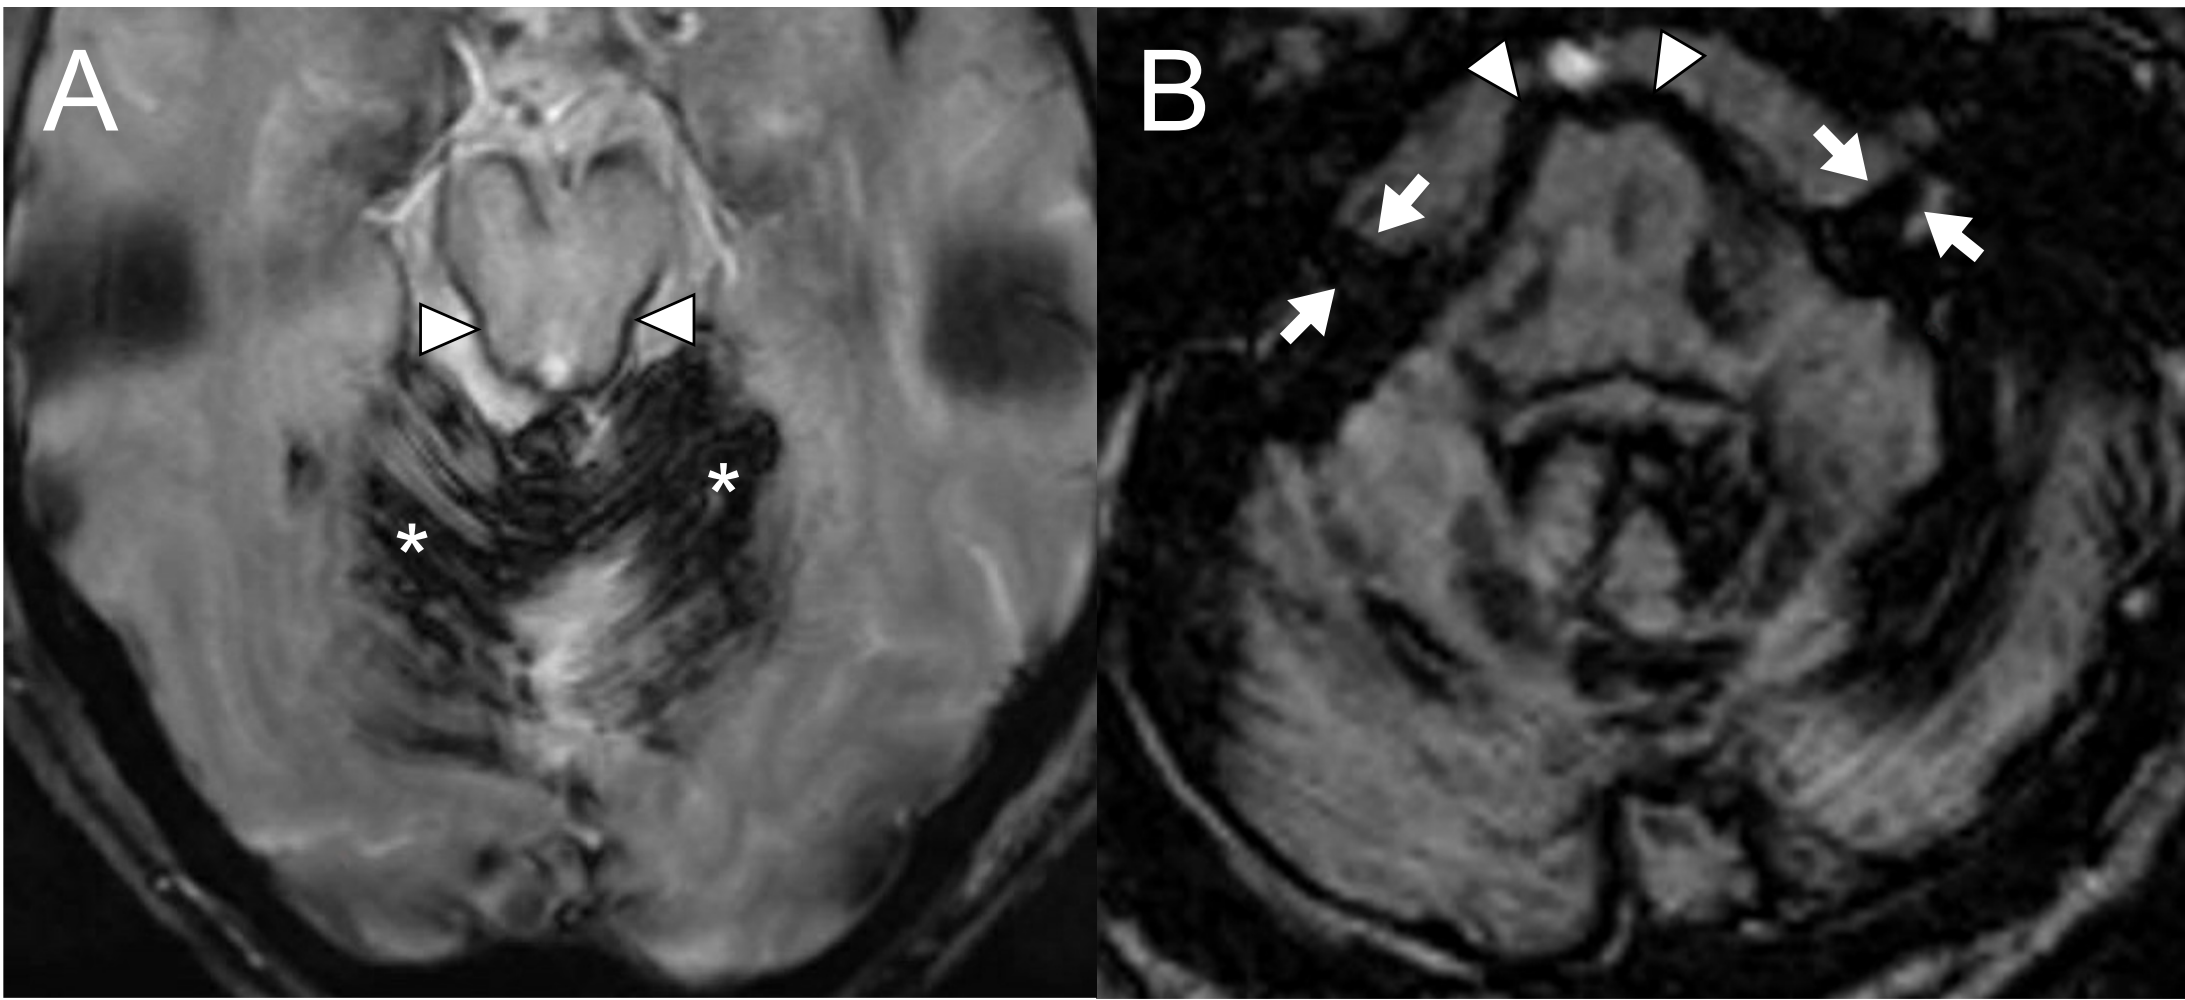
Axial susceptibility-weighted MR images with signal loss typical for iSS, involving cerebellum (asterisks, A), brainstem (arrowheads: midbrain, A; pons, B), and 8th cranial nerves (arrows, B).
